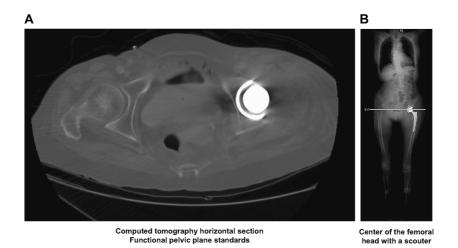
A, Computed tomography (CT) horizontal-section functional pelvic plane criteria; B, CT scouter used to identify the center of the femoral head.
